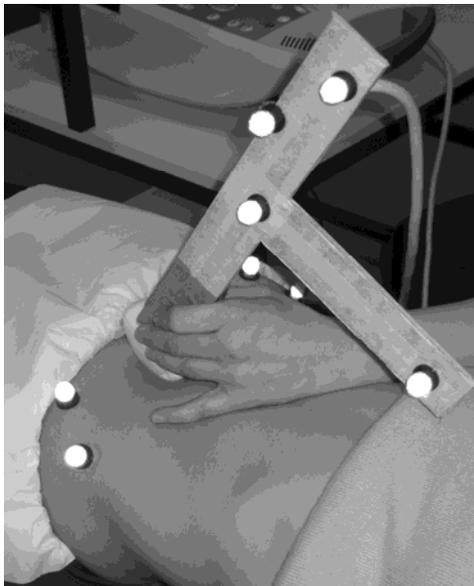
Experimental set-up for motion analysis (of transducer) and USI at the sagittal bladder imaging site. Note the retro-reflective markers on the ASIS's, iliac tubercle's and wand attached to the ultrasound transducer.
